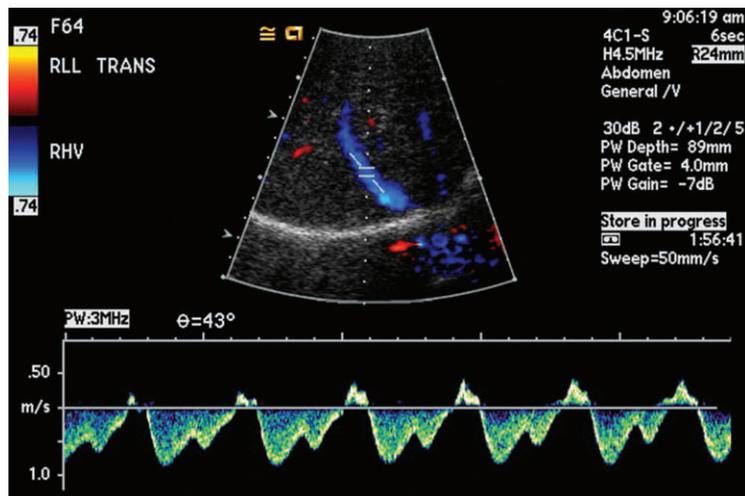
Duplex Doppler display on the Sequoia 512 unit. The left portion of the two-dimensional display has the color scale for the color Doppler image; flow toward the transducer is indicated with shades of red and yellow, whereas flow away from the transducer is indicated with shades of blue and green. The upper right portion of the display lists various technical parameters, including which transducer was used. The central portion of the display has the color Doppler image, with the Doppler gate over the right hepatic vein in this case. Note that flow is appropriately away from the transducer toward the retrohepatic IVC. The bottom portion of the display shows the spectral Doppler waveform, in which blood flow velocity (in meters per second or centimeters per second) within the Doppler gate is plotted versus time.
